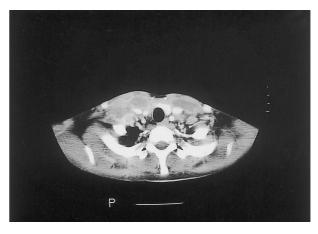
CT scan of the neck showing bilateral supraclavicular lymphadenopathy.
